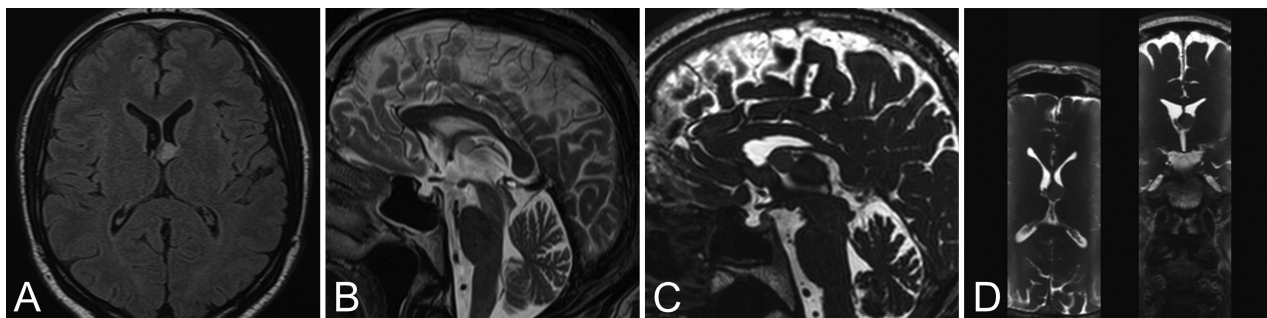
Initial MR images obtained after the patient presented with symptoms and was referred to the neurosurgery team, revealing a hyperintense CC in the third ventricle near the foramen of Monro on FLAIR (A) and T2-weighted (B–D) sequences, without evidence of hydrocephalus.
